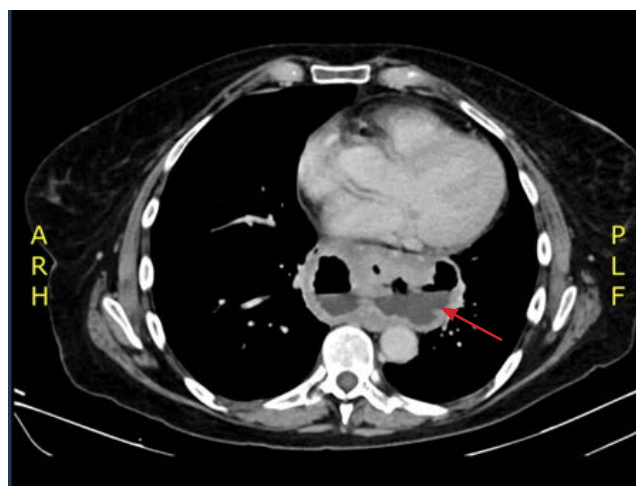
Axial CT chest demonstrating intrathoracic herniation of the stomach (red arrow) through the oesophageal hiatus
